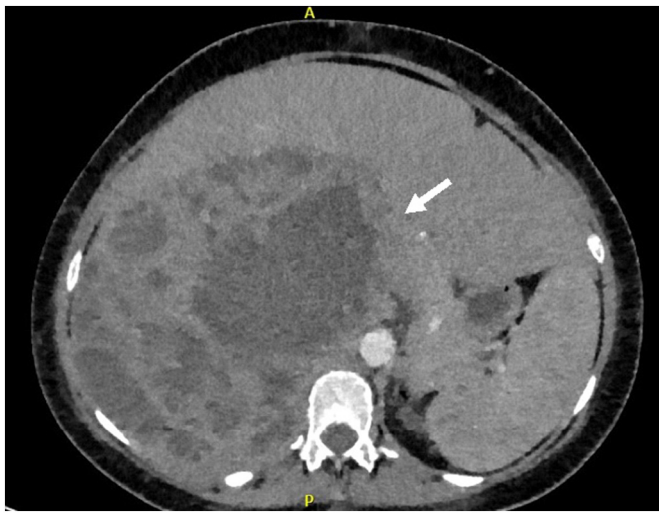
CT Angiography of the Chest. Lower cuts of the chest revealing a large 19×14 cm heterogeneous and enhancing septated and multi-loculated mass (arrow), arising from the upper pole of the right kidney. There is secondary mass effect on the adjacent organs with elevation of the right hemidiaphragm and underlying atelectasis. As initial expression, this could represent a hydatid cyst versus a septated multicystic nephroma.
